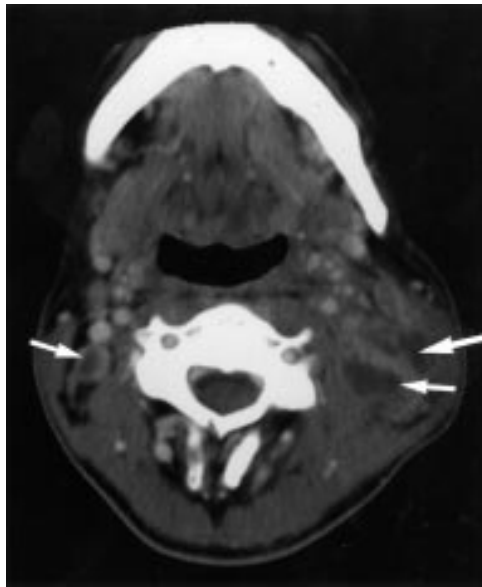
CT scan of the neck showing multiple, up to 2 cm diameter, highly vascular nodes, with low attenuation centres (arrows), on both sides of the neck, more markedly on the left than the right.
